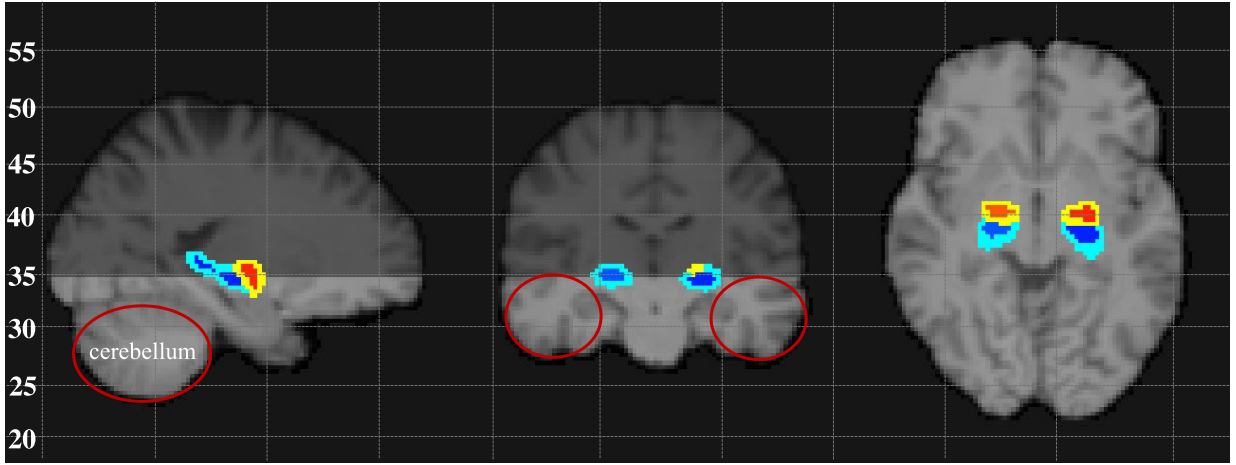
An example of MRI data used in the brain age prediction models representing the sagittal (left), coronal (middle), and axial (right) planes of the image after the minimal preprocessing and normalisation to the MNI152 space using FSL software. The hippocampus is highlighted in blue, while the amygdala is highlighted in red. The cerebellum is circled in red. The numbers on the left represent the values of the z-axis used for image cropping; these values are not to scale. Cropping was performed at $z = 35$ to include the cerebellum and the majority of the hippocampus and amygdala.
